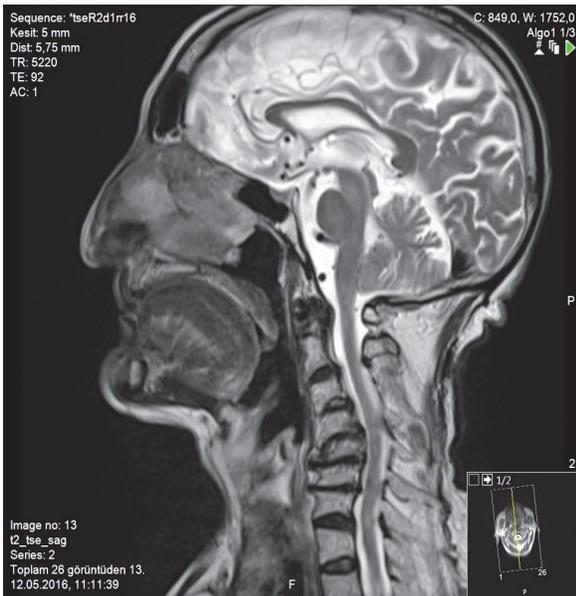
In the T2 weighted MRI on sagittal plane between the anterior part of the C3-C6 vertebrae, degenerative and osteophytic changes are seen.
